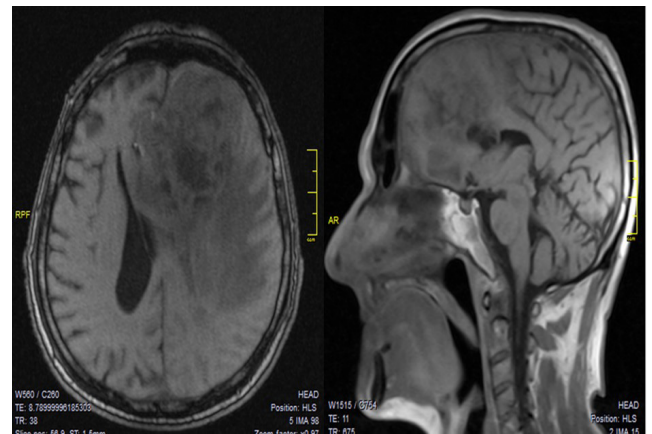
MRI examination showed a mass located in the left frontal lobe.
